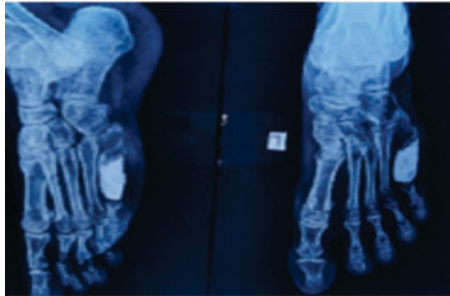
Xray after recurrence
